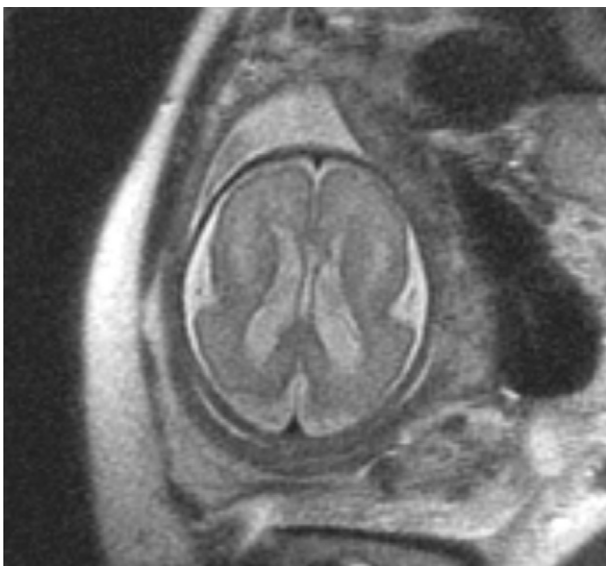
Magnetic resonance imaging of the fetal brain at 29 weeks of gestation shows agyria, a “figure-of-eight” appearance of the brain, a wide and shallow sylvian fissure, and dilated lateral ventricles.
